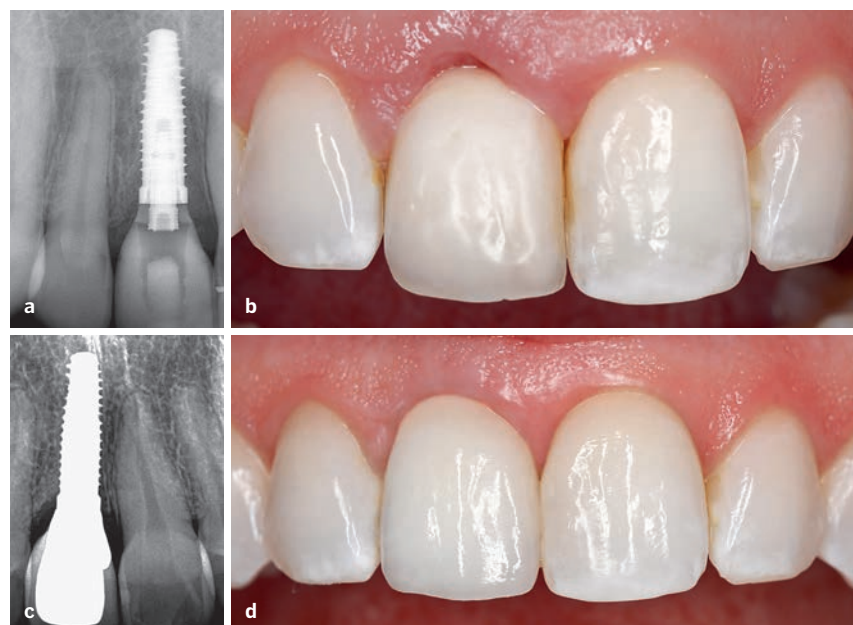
This patient suffered a traumatic injury that resulted in such substantial damage to the maxillary right central incisor that it could not be retained. (a and b) An implant was placed immediately upon extraction of the tooth, and a provisional crown was delivered at the time of implant placement. The radiograph shows the temporary abutment in the implant and the provisional crown. The clinical photo shows the mucosa at the time of provisional crown delivery. (c and d) Definitive crown in place. The clinical photo shows the healed mucosa around the implant.
